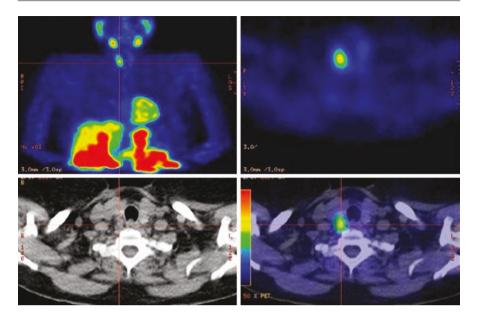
Single photon emission computed tomography (SPECT)/CT showing a right parathyroid adenoma
